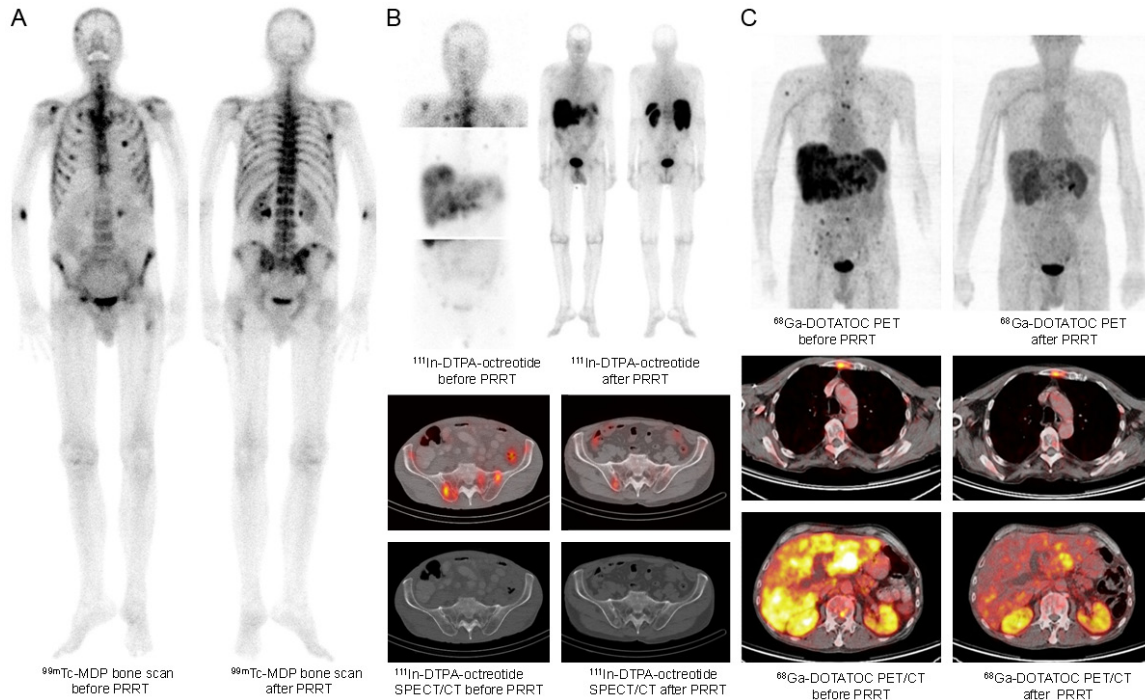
Initial response to PRRT of the same patient as in Figure 6: A: ^{99m}Tc -MDP whole body bone scan images before PRRT. B: ^{111}In -DTPA-octreotide images before (left) and after PRRT (right), above: planar images, below: fused SPECT-CT images. C: ^{68}Ga -DOTATOC PET/CT images before (left) and after PRRT (right), above: maximum-intensity-projection PET images (coronal view), below: fused PET-CT images.
